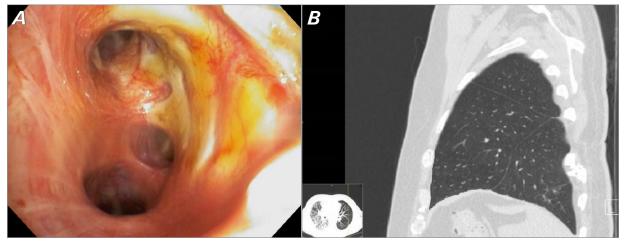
Shown are A) postoperative bronchoscopy and B) posttransplant computed tomographic image.
